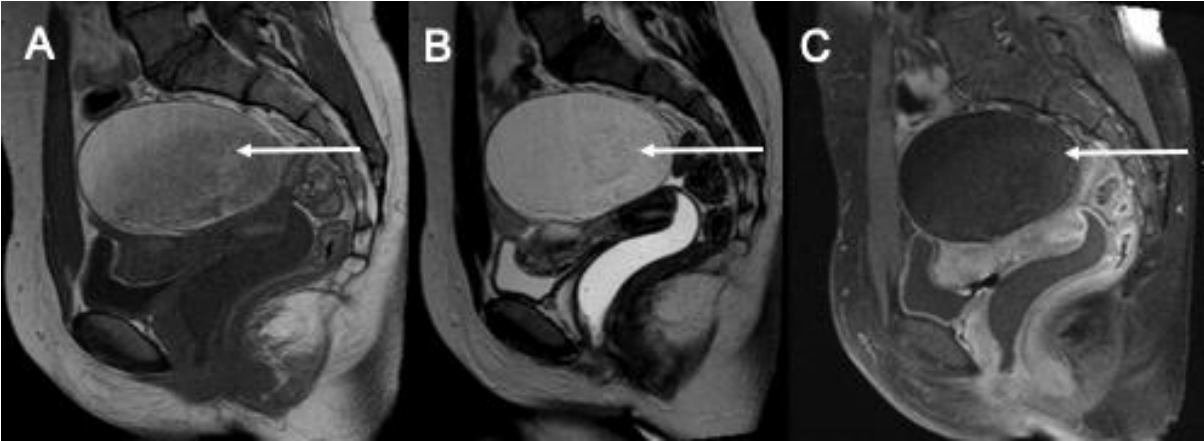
MRI of a unilocular MCT: a unilocular cyst with homogenous high signal on T1-weighted (A) and T2-weighted images (B), with loss of signal on T1-fat suppression (C) corresponding to adipose tissue.
